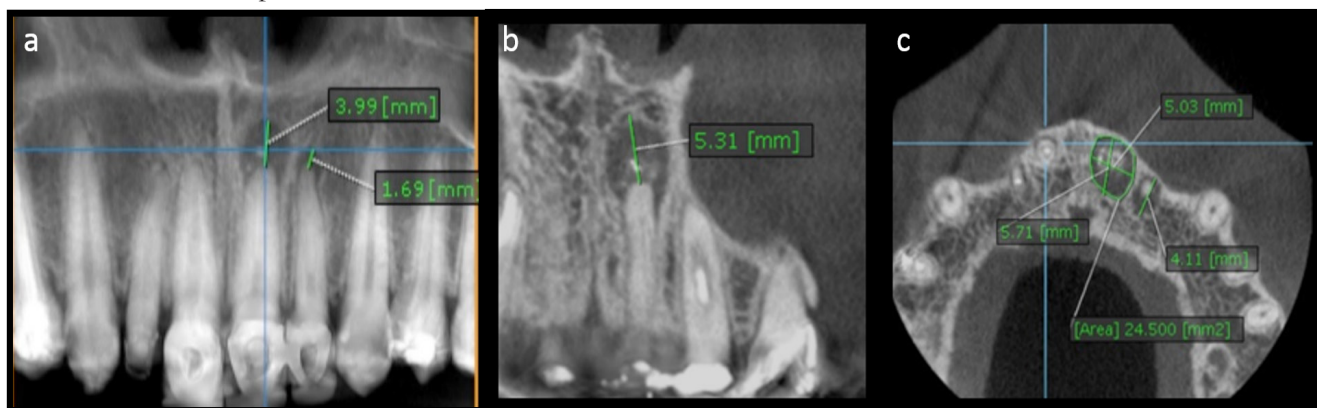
a) Radiographically visible periapical lesions on teeth 2.1. (3,99 mm diameter, CBCTPAI score – 3) and 2.2. (1,69 mm diameter, CBCTPAI score – 2). b) Coronal section shows that the diameter of the lesion has increased to 5.31 mm and subsequently the CBCTPAI score is 4. c) The axial section shows a biggest area of periapical lesion and has been determined as being 24.5 mm².
